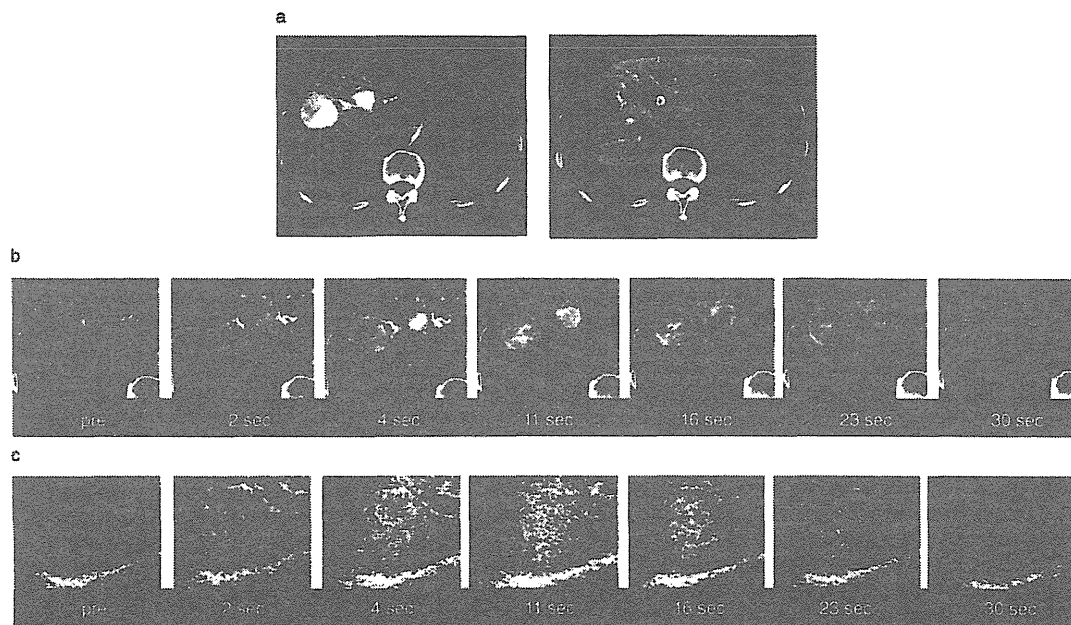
A 71-year-old male with HCC 4.2 cm in diameter in segment 8. (a) Images of CTHA (left) and CTAP. Tumor was enhanced on CTHA and showed a flawed image on CTAP. Hypervascular tumor in segment 4 is also depicted. (b) Images of the tumor on single-level dynamic CTHA, which was performed just before and 2, 4, 11, 16, 23 and 30 s after injection of contrast material from the appropriate hepatic artery. (c) Images of the tumor on US during hepatic arteriography taken at the same times before and after injection of contrast material from the same place. A slightly larger area became enhanced in (c) 11 s after the start of enhancement. Enhancement of the real tumor area became faint and corona enhancement became visible. Images of ordinary contrast-enhanced US are not shown here because they were not obtained serially with the same dimensions. CTAP, computed tomography during arterial portography; CTHA, computed tomography during hepatic arteriography; HCC, hepatocellular carcinoma; US, ultrasonography.
